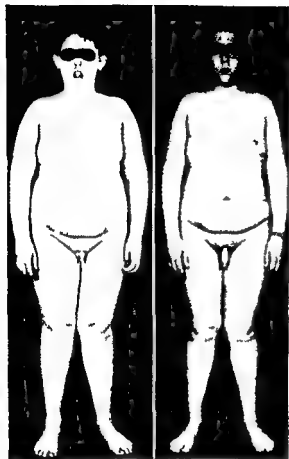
CRYPTORCHIDISM OBESITY AND HYPOGENITALISM IN A BOY ABOVE AVERAGE HEIGHT (See also Fig 1, and Chart 10) *Chief complaint* Obesity. *History of present illness* Overweight since the age of 3. Retarded genital development. Undescended testes noted at the age of 5. From the age of 6 chorionic gonadotropin had been administered almost continuously until the age of 8. Testosterone propionate 5 mg. was then given weekly for 1 year. (Patient has been treated elsewhere.) Testes descended. Perfectly well. *Physical examination* Age 10 Height 57½ in. Height age 12½ years Testis volume 2 cc. Photograph (left) taken at age 12. *Laboratory data* Urinary hormone assays: FSH (unconcentrated) negative and 17 ketosteroids 9.3 mg./24 hrs. *Roentgenographic findings* Bone age 12½ years. (Right) Age 13 years Weight 156 lbs Height 63½ in. Some pubic hair. Penis 3.6 in. Testis volume 10 cc. After cessation of therapy progress continued.
